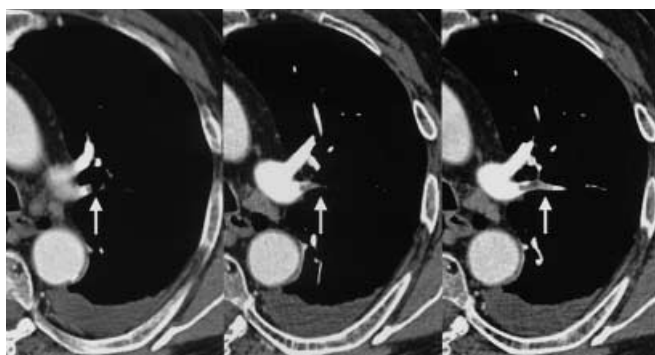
A 70-year-old man. Three-millimeter (left) and 2-mm (middle) axial reconstructions of a contrast-enhanced multislice CT data set suggest the presence of thrombus in a segmental artery supplying the posterior segment of the left upper lobe of the lung (arrows). Only 1-mm reconstruction (right) of the data set allows following the entire course of the segmental artery and unanimous visualization of the filling defect within the posterior subsegmental branch
